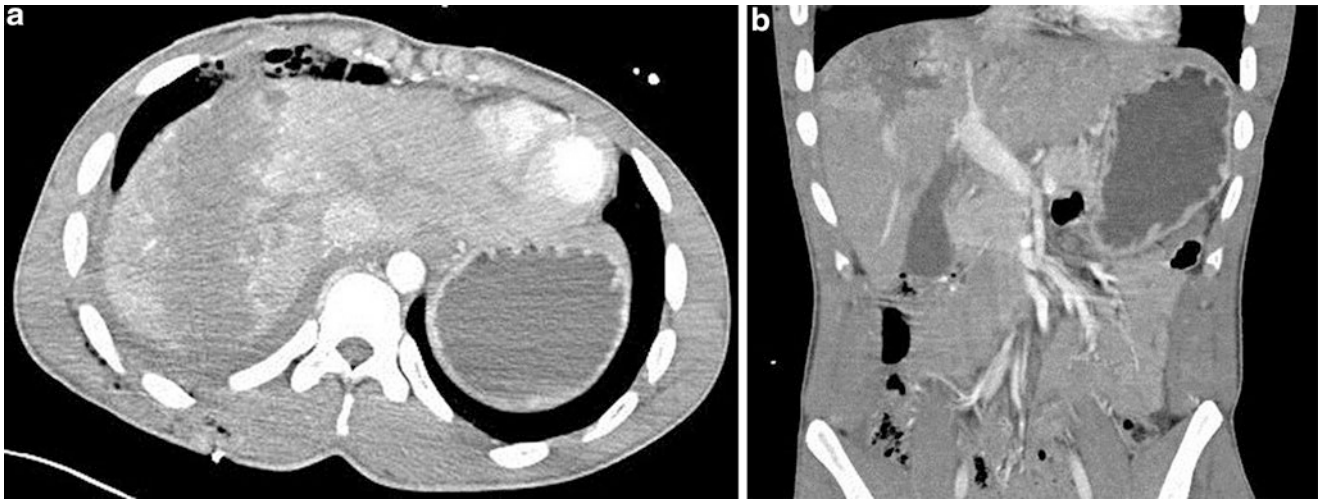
Nonoperative management was used in this hemodynamically stable 15-year-old boy following an isolated transabdominal gunshot with entrance wound above the right costal margin anteriorly and exit wound beneath the right scapular tip. (a) Axial abdominal CT
